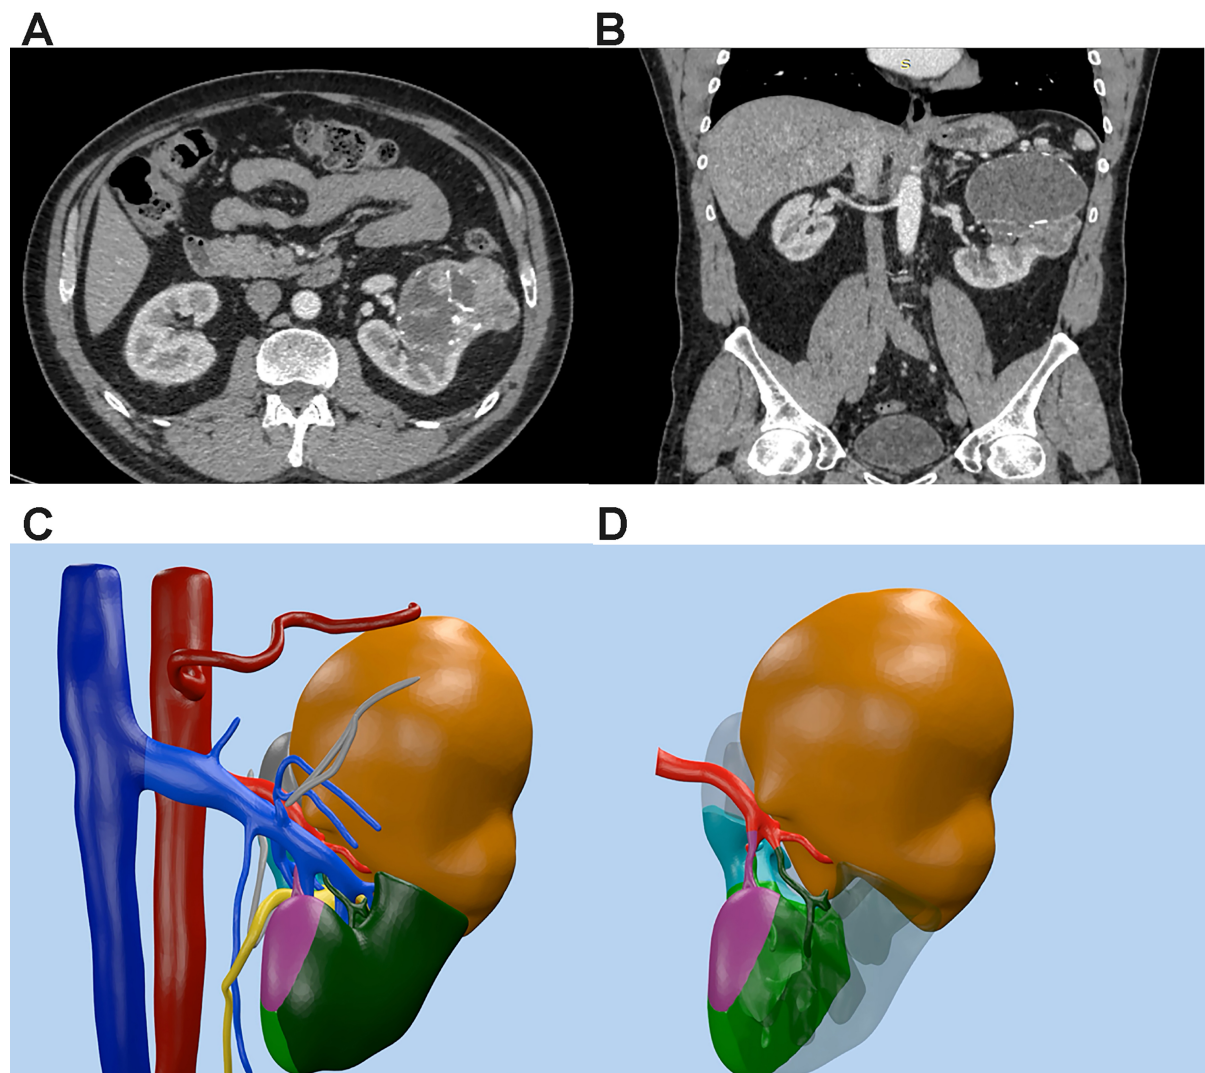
CT findings of patients with CRM and 3DVM preoperative reconstruction - rainbow technology. (A and B) Axial and coronal CT scan of high complexity renal cell carcinoma (RENAL = 12); (C and D) 3DVM reconstruction (red represents artery, blue indicates vein, and yellow stands for collective system. Brown denotes tumor). CRM: Complex renal masses; 3DVM: 3D vascular model.
